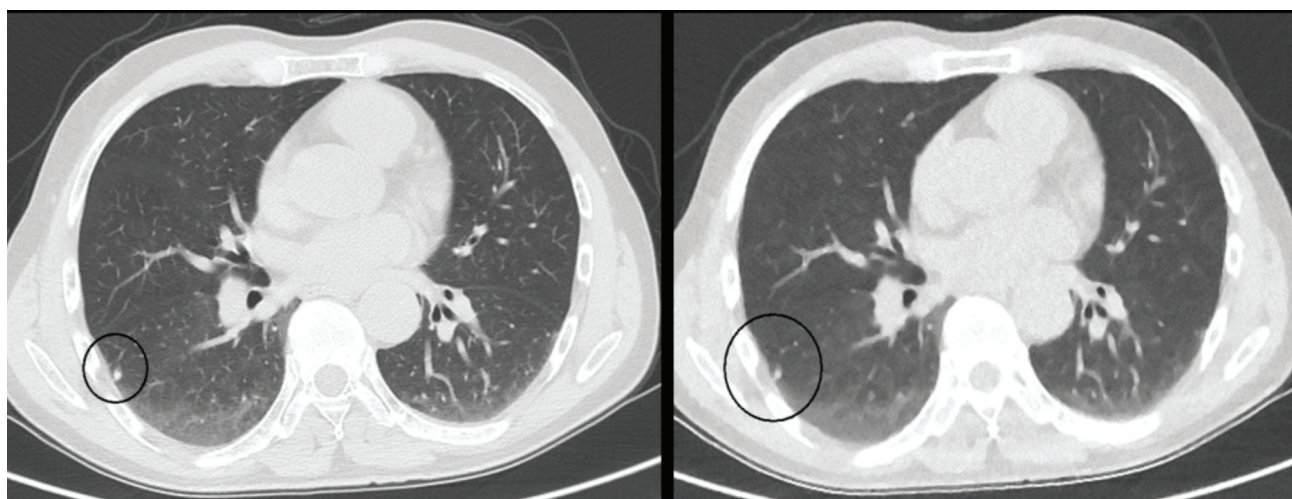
This figure shows the standard dose (a) and Ultra-low dose (b) chest CT in a patient with cough and over 30 years of smoking (the black circle shows small lung nodule at the center).
